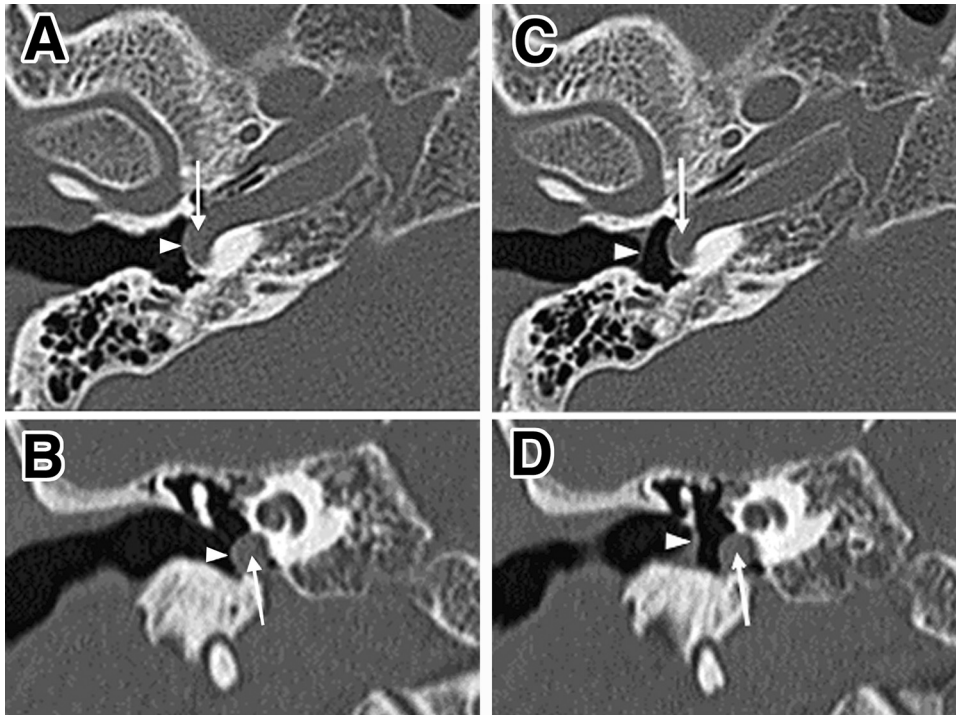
Preoperative (A: axial, B: coronal) and postoperative (C: axial, D: coronal) CT images of the aberrant ICA. (A and B) An aberrant course of the right ICA was demonstrated through a dehiscent lateral carotid plate (arrows). The tympanic membrane made a contact with the ICA (arrowheads). (C and D) After the operation, there was enough space between ICA (arrows) and tympanic membrane (arrowheads).
